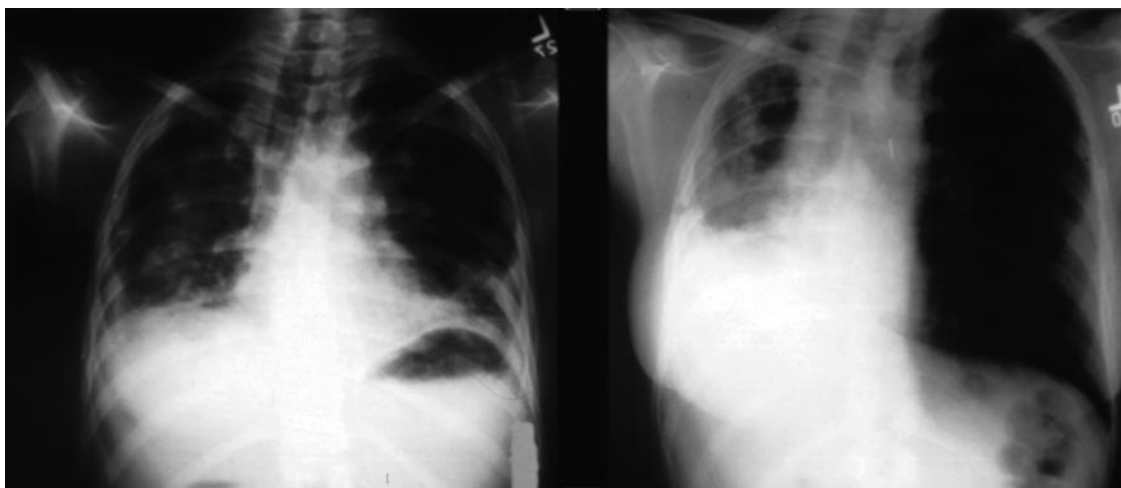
Posteroanterior chest radiograph of a patient with interstitial lung disease before (left) and after (right) a left-side single-lung transplant procedure.
